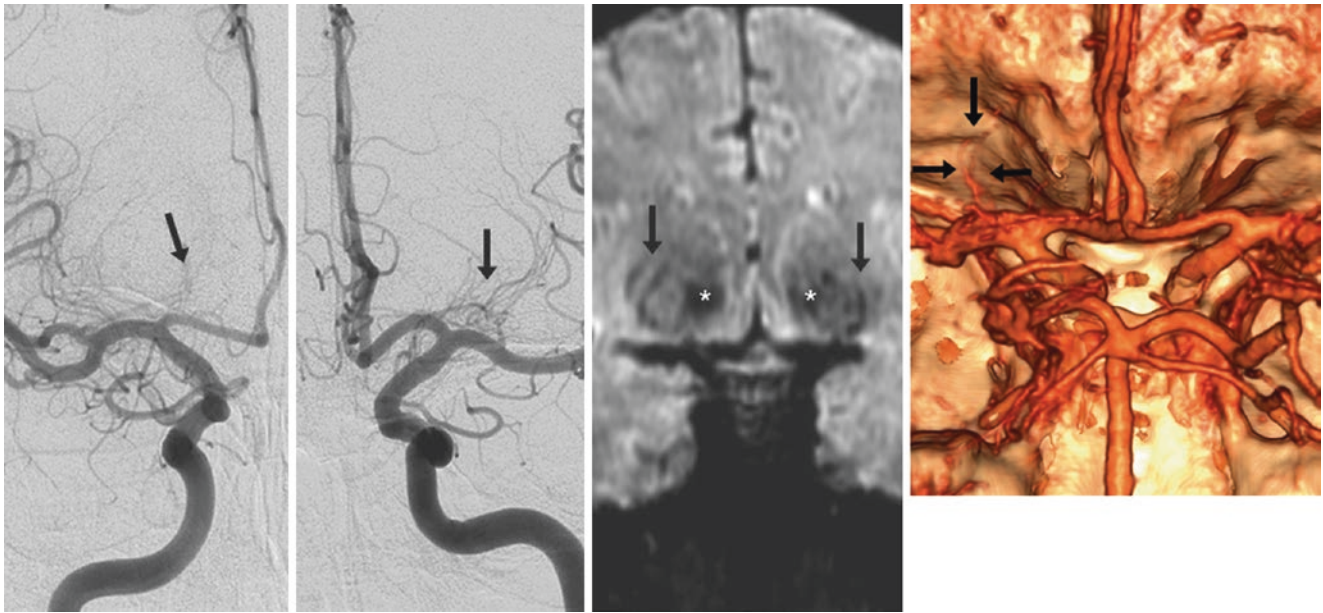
46-year-old with prominent left (but faint right) lenticulostriate branches (*arrows*) from the ICA termini at the proximal ACA and MCA segments, on AP views from catheter DSA (*left and left middle*). Coronal SWI MRI (*right middle*) demonstrates left lenticulostriate
